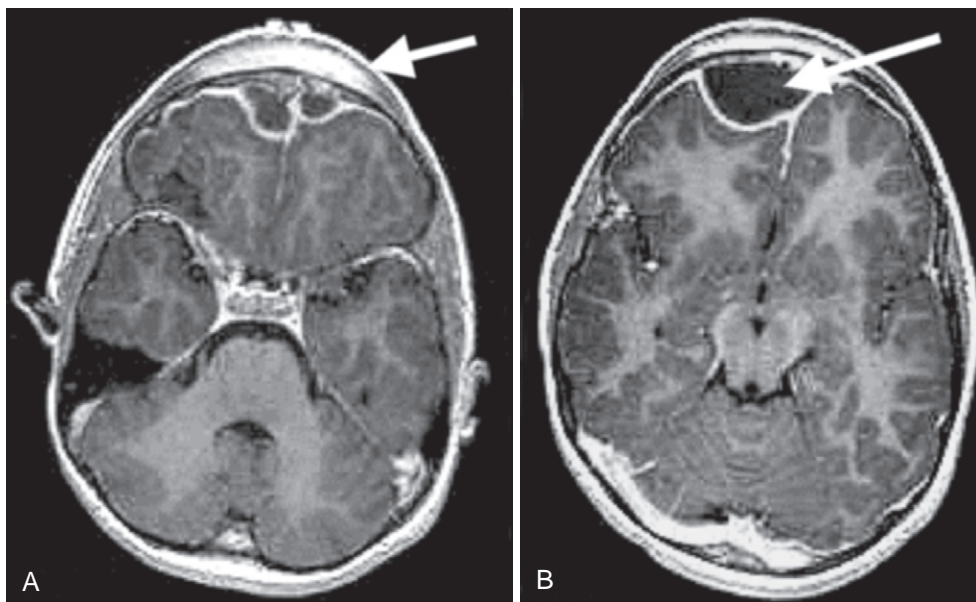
A and B, Axial magnetic resonance images from a 5-year-old boy with a history of strep throat, treated with 2 weeks of oral antibiotics, followed by fever, malaise, headaches, progressive swelling in the midline of his forehead, vomiting, and lethargy. A frontal subperiosteal abscess (i.e., Pott puffy tumor; A, arrow) and an epidural abscess (B, arrow) are evident. He was managed by surgical evacuation and aggressive antibiotic therapy; the bone flap was left in place. The infection resolved completely with no neurologic sequelae.
